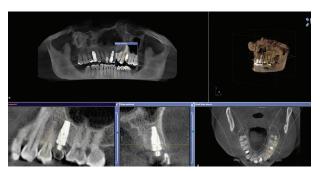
Updated CBCT for implanting planning #12 and to assess previously placed implant #13
